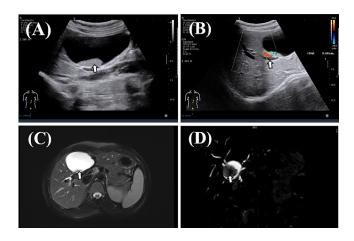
Preoperative imaging. (A) Ultrasound imaging of the intrahepatic bile duct cyst and its internal deposits: the S4 segment of the liver contained an anechoic area with a clear boundary with an iso-echoic mass inside (arrow), which can be moved by changing the body position with no sound shadows behind. (B) Ultrasound imaging of the dilated intrahepatic bile duct and color Doppler. No blood flow signal could be detected by color Doppler in the iso-echoic area. The arrow indicates the worm in the biliary tract. (C) Magnetic resonance images (MRI) of intrahepatic bile duct dilatation, cysts, and their internal deposits (arrow). (D) MRCP images of intrahepatic bile duct dilatation, cysts, and their internal deposits (arrow).
